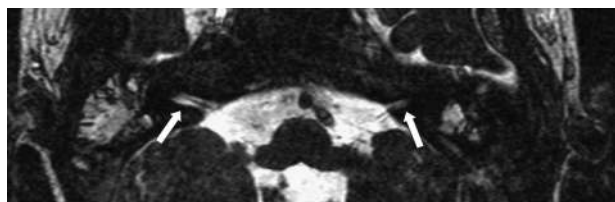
Axial MRI (T2, ciss-3-dimensional sequence) of the IAC. Bilateral aplasia of the cochlear nerve (arrows).
